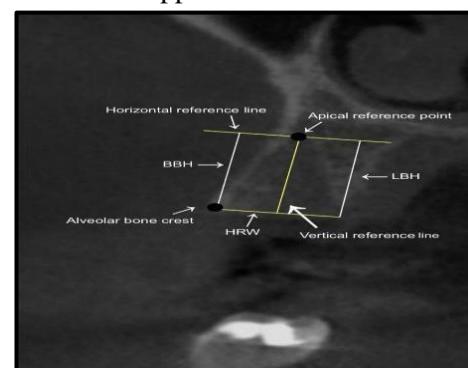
CBCT radiograph measurement of BBH: Buccal bone height, LBH: Lingual bone height, and HRW: Horizontal ridge width.
